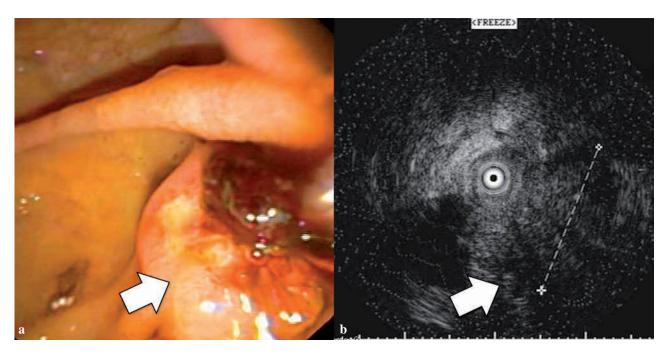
a) Duodenoscopic aspect of ampullary carcinoma with malignant ulcer (indicated by arrow). b) Application of IDUS in the same patient. Malignant lesion of the ampulla of Vater showing typical ultrasonographic characteristics in terms of inhomogeneous echo of the tumor with infiltration into the sphincter of Oddi and the duodenal wall (indicated by arrow).
